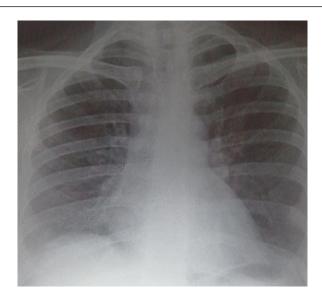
Chest X-ray on follow up showing drastic improvement in lung lesions.
